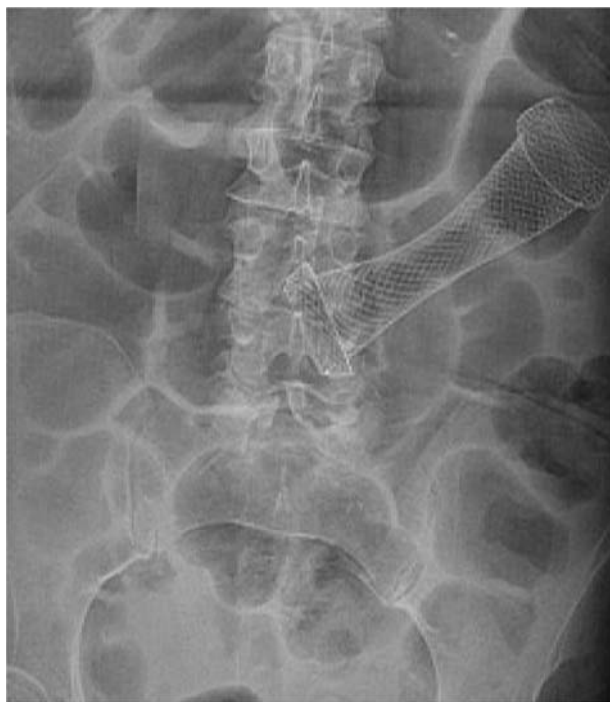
Plan survey radiograph of the abdominal cavity immediately after self-expanding intestinal stent placement into the sigmoid colon
